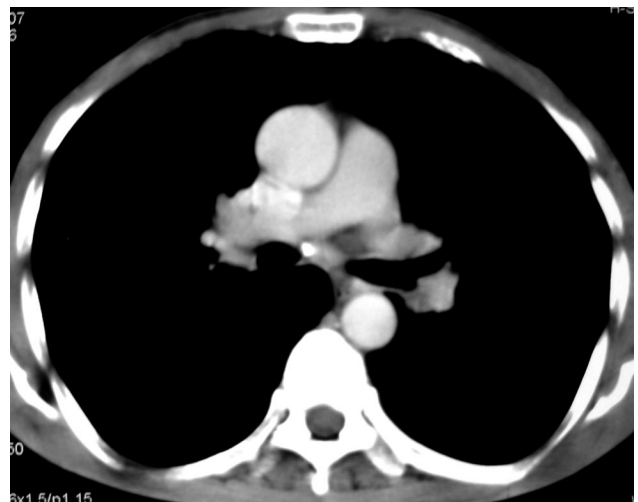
Computed tomogram shows no hilar/mediastinal lymphadenopathy.
